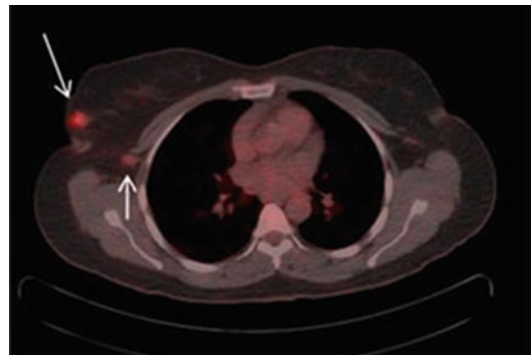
Fused PET/CT transaxial image of [^{18}F]FDG-avid right breast lesion and ipsilateral axillary lymph node
